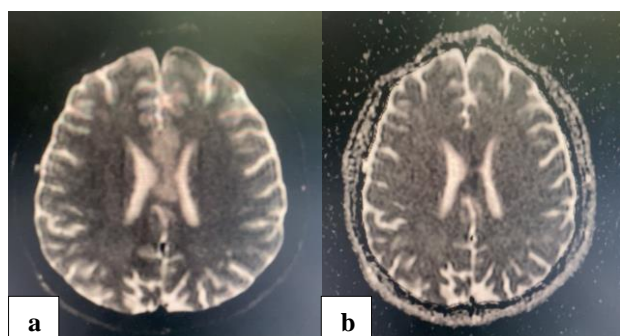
Axial cut MRI DWI sequence showing hyperintensities and ADC sequence showing signal drop out at the body of the corpus callosum.
